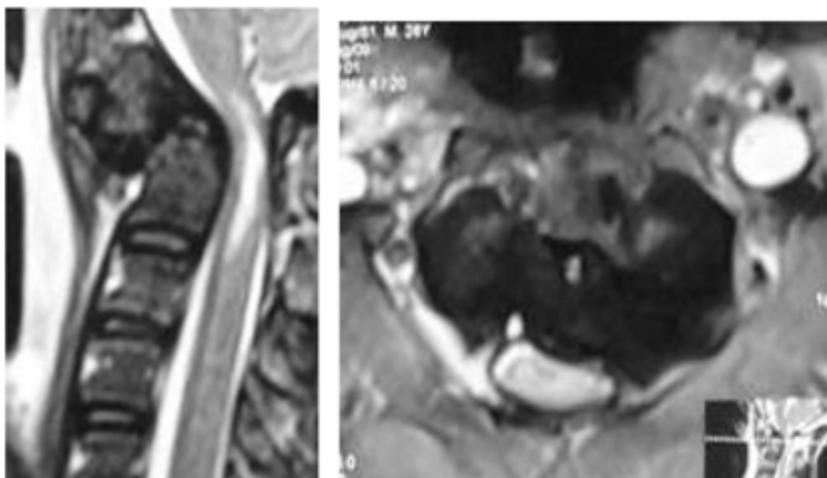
MRI showing high intensity signal change in the high cervical cord.
